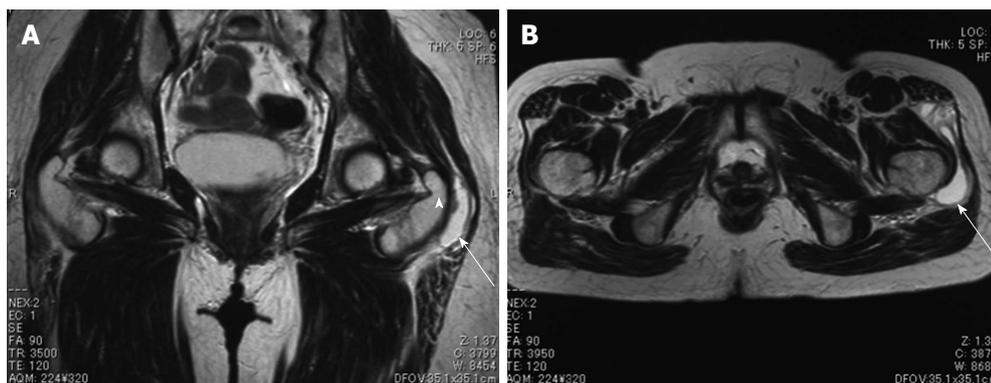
A 58-year-old female with greater trochanteric bursitis. Coronal (A) and axial (B) T2-weighted magnetic resonance images of a cyst located at the characteristic position of the left greater trochanteric bursa (arrow). Arrowhead: Greater trochanter.
